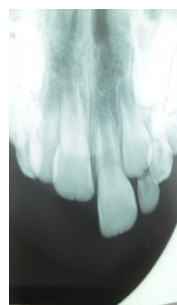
An intraoral periapical X-ray showing intruded upper right central incisor with an open apex
